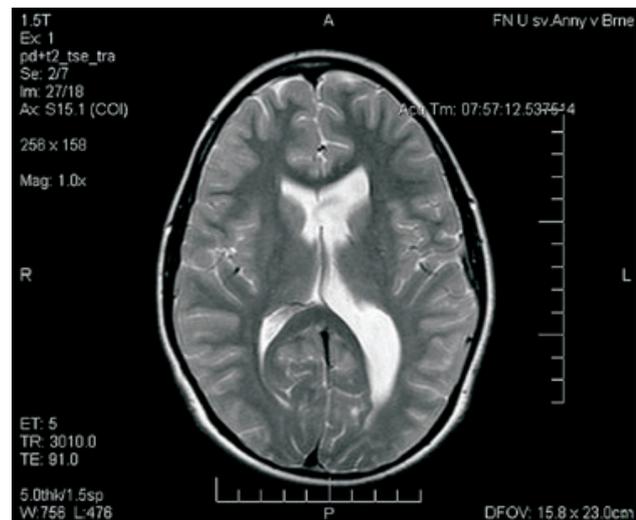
MRI visualization of cerebrospinal fluid flow through the septostomy.
